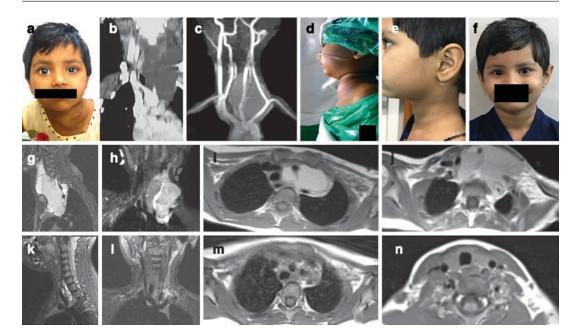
A 5-year-old female presented with a mass on the left side of the neck and supraclavicular region causing left-sided Horner's syndrome. (a) Clinical photograph at presentation showing swelling in the left side of the neck as well as miosis and enophthalmos in the left eye and neck swelling. (b) Preoperative CT scan in Sagittal reconstruction Preoperative computed tomography of the neck showing a cystic vascular malformation encasing and (c) displacing the major great vessels from the root of aorta. (g, h, i, j) Preoperative magnetic resonance imaging sagittal, coronal and axial section showing a cystic lesion in the anterior triangle of neck encasing and displacing vital structures of the neck like great vessels—Common carotid, vertebral and left subclavian artery. The trachea is
